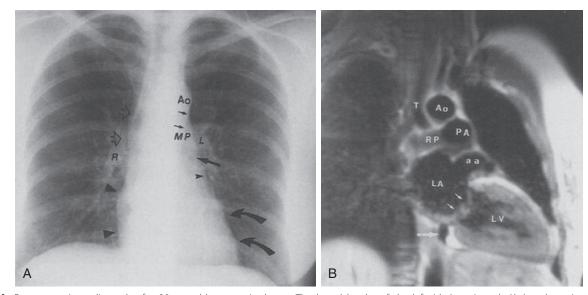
A, Posteroanterior radiograph of a 30-year-old woman is shown. The lateral border of the left-sided aortic arch (Ao) and proximal descending aorta *(short arrows)* are clearly seen. The main (MP) and proximal left (L) pulmonary artery are seen cephalad to the left bronchus *(long arrow)*. The left atrial appendage section *(small arrowhead)* is inferior to the crossing of the left bronchus and cephalad to the left ventricular contour *(curved arrows)* of the left heart border. The superior vena cava is not seen on this examination. However, the ascending aorta *(small open arrow)* is seen barely over the hilar right pulmonary artery (R). The right atrial appendage section *(large arrowheads)* extends just to the right of the spine. B, Spin-echo MRI obtained from a different 30-year-old woman is shown. The left heart border–forming structures are the aortic arch (Ao), which is to the left of the trachea (T), the distal main pulmonary artery (PA), left atrial appendage (aa), and anterolateral portion of the left ventricle (LV). The transverse right pulmonary artery (RP) passes over the left atrium (LA). Notice that the Ao and PA are equal in caliber. The mitral valve *(small arrows)* and coronary sinus *(large arrow)* are shown. *(From Boxt LM: Plain-film examination of the normal heart*, Semin Roentgenol 34:169-180, 1999.)
